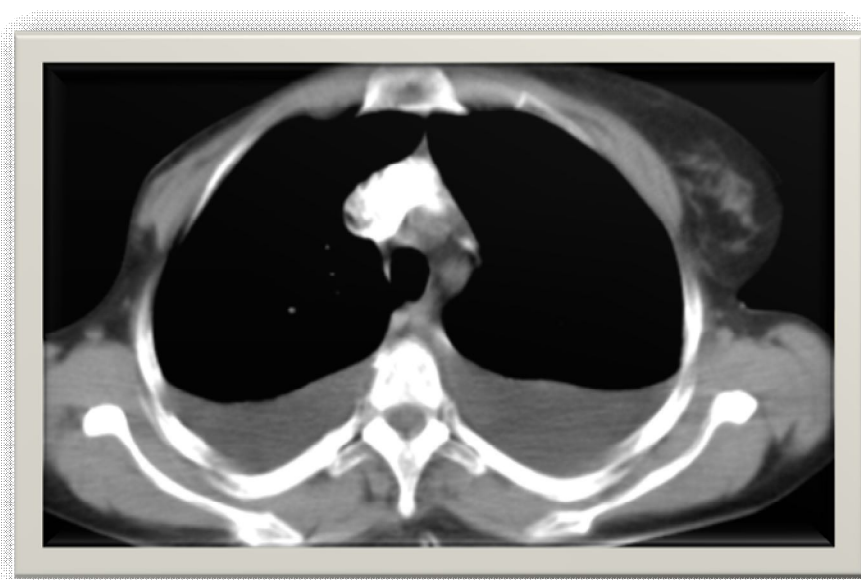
Axial CT scan of the chest for a 32 year old female with bilateral haemothorax
